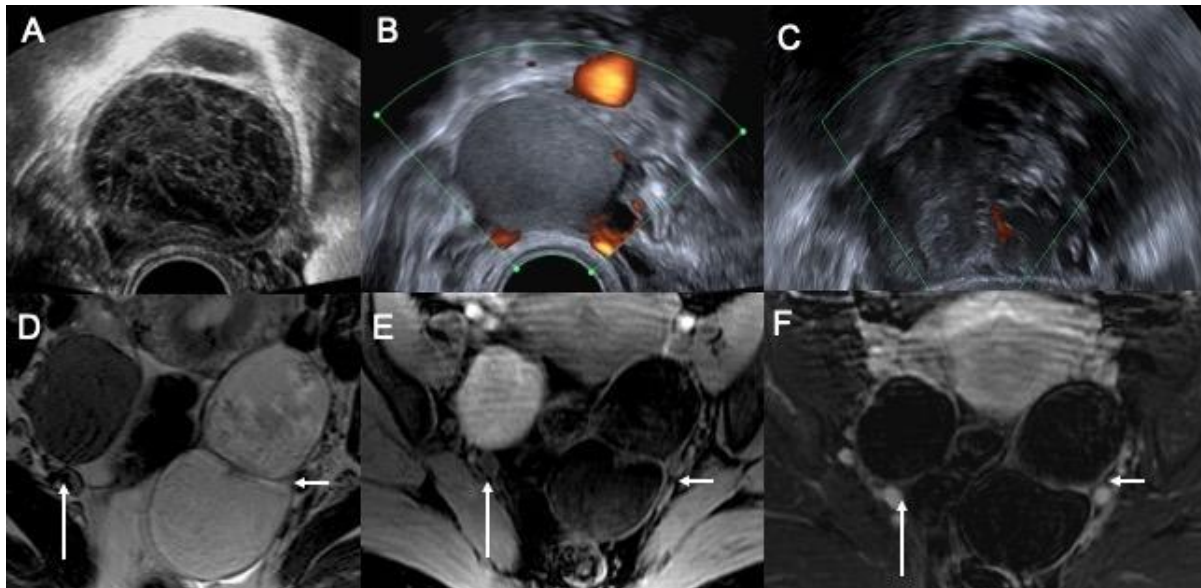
Differential diagnosis. In US: A) Functional hemorrhagic cyst; B) Endometrioma; C) cystadenofibroma. Differential diagnosis on MRI (D-F). There are bilateral ovarian cystic lesions. Right ovary (long arrows) has a unilocular cystic mass with T2-shading (D), hyperintensity on T1-fat saturated (E), and subtle wall enhancement after contrast (F) consistent with an endometrioma. Left ovary has a bilobed cystic lesion (short arrows) with a high signal component on T2 (D) that loses signal on T1 FS (E) and also subtle, subtle wall enhancement after contrast (F) consistent with an MCT.
